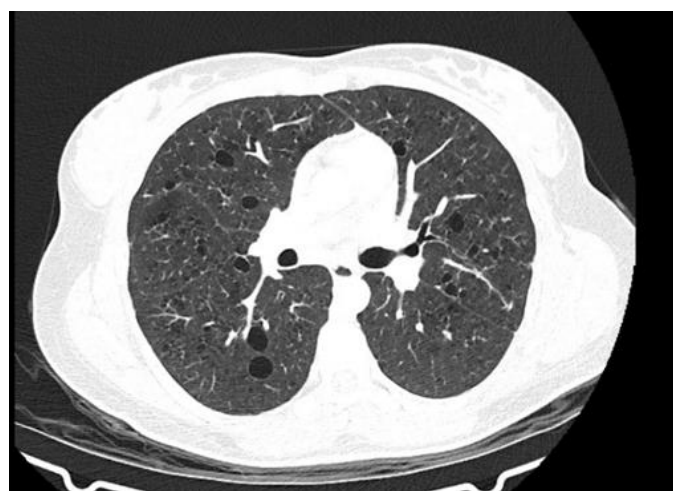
HRCT showing cysts of varying sizes in middle zone of bilateral lung fields.
